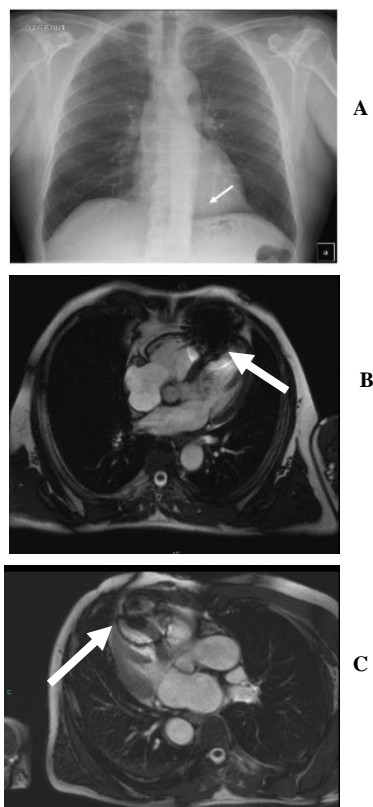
A) Thoracic x-ray, B, C) MRI and D, E) CT-scan images at 5 months after material removal: the metal tip was found in the right ventricle (white arrow).
